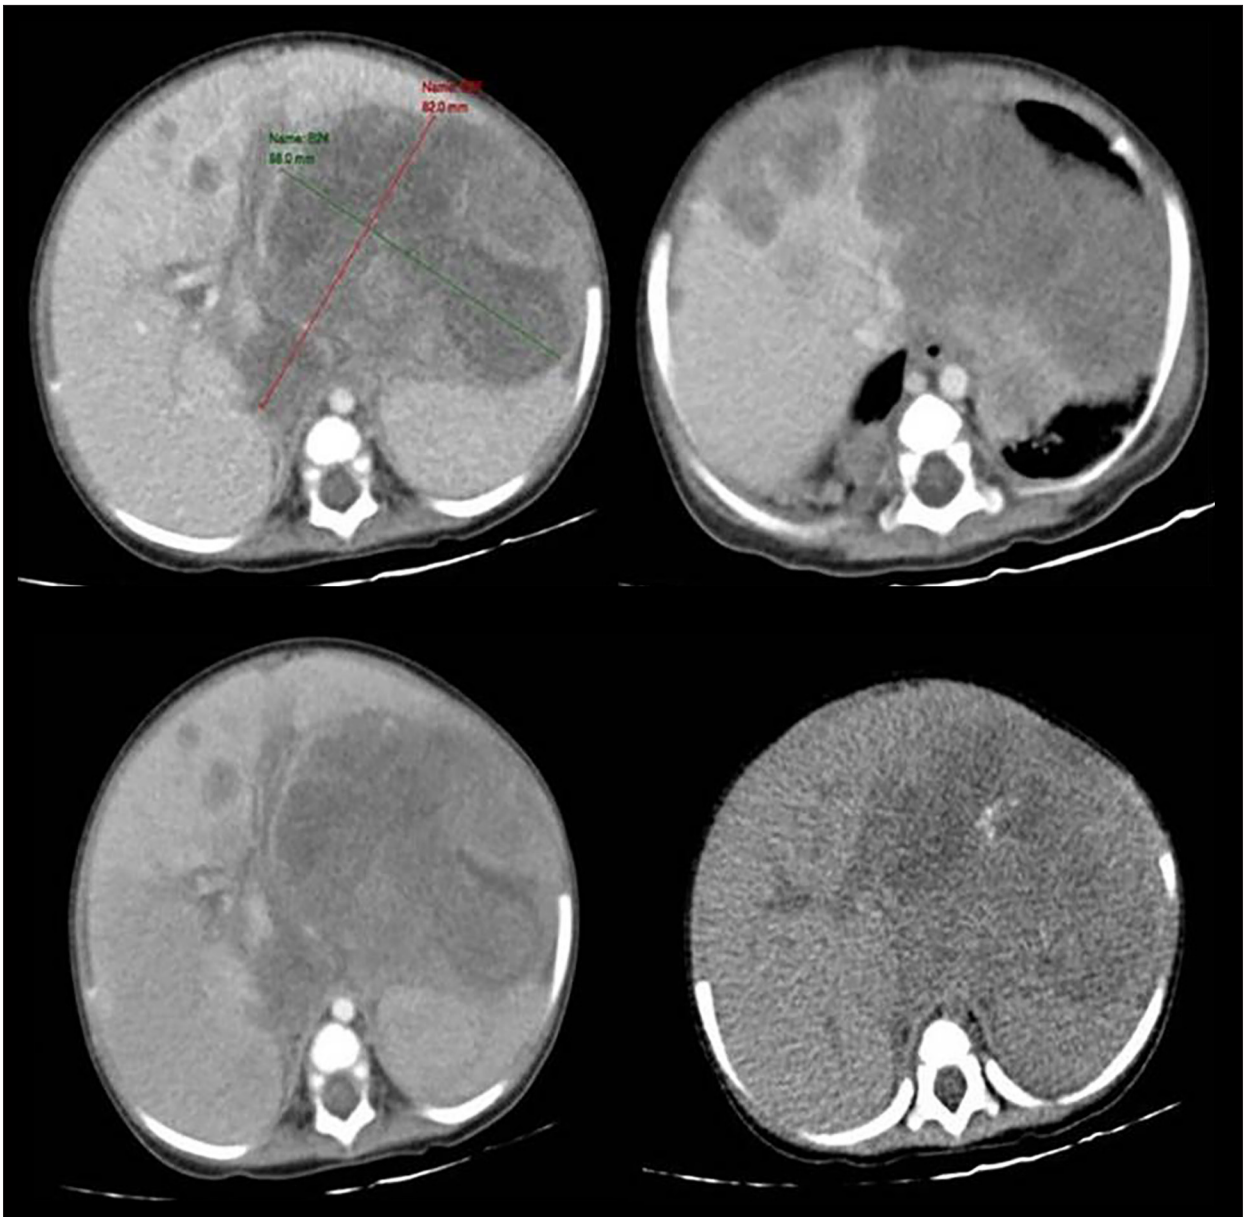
Abdominal computed tomography shows large heterogeneous enhancing soft tissue mass of the liver with central necrosis and lobulated outlines located in the left upper quadrant.
